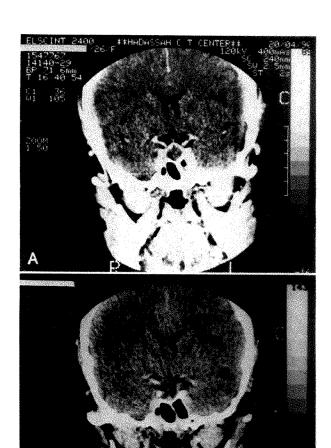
A, Computed tomographic scan of brain demonstrating pituitary infarction with decrease in gland size. B, Repeat computed tomographic scan of brain shows almost total disappearance of pituitary tissue consistent with empty sella.
